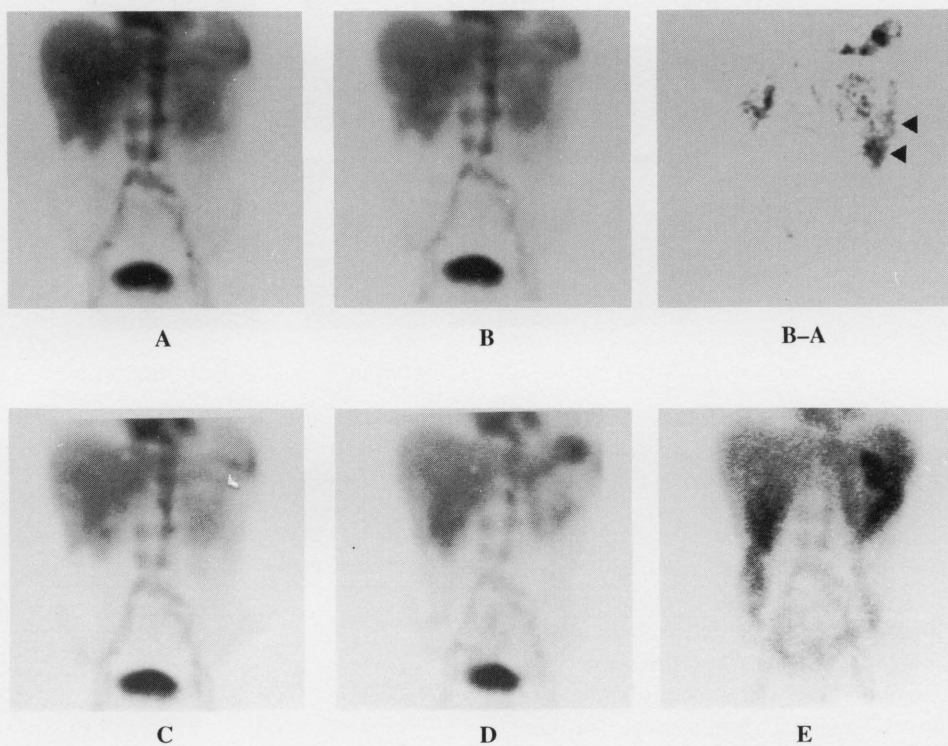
A 79-year-old man with bleeding from small intestine due to metastatic cancer. Conventional abdominal scintigrams with ^{99m}Tc -RBC at 30 (A), 35 (B), 60 (C), 180 (D) min and 20 (E) hr after injection. Abnormal accumulation of the tracer is seen in the LUQ at 180 (D) min and more apparent throughout the colon at 20 (E) hr. A subtraction scintigram (B-A) by 35–30 min images shows the site of bleeding in the LUQ (arrows) at an early time. Free ^{99m}Tc -pertechnetate is observed in the region of stomach.
